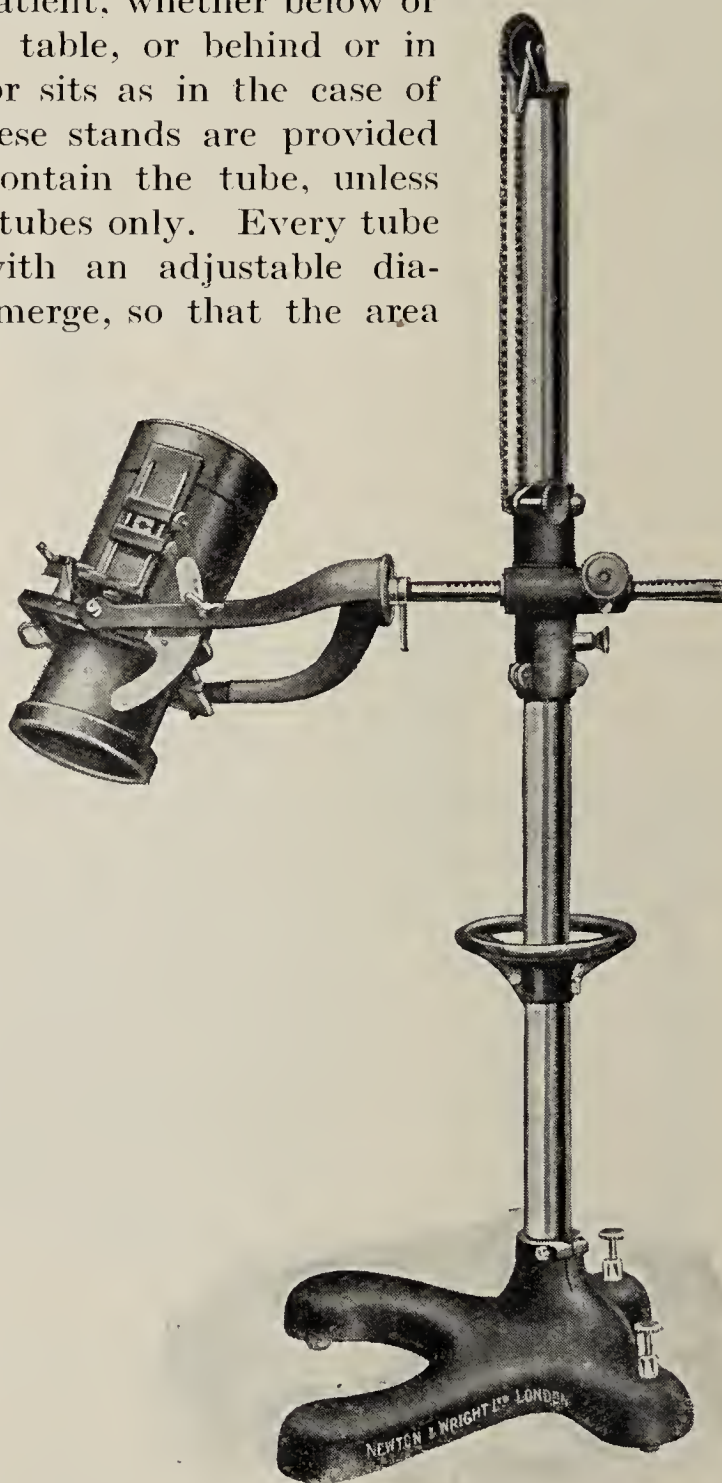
X-RAY TUBE-HOLDER, CYLINDER DIAPHRAGM, AND COMPRESSOR.
